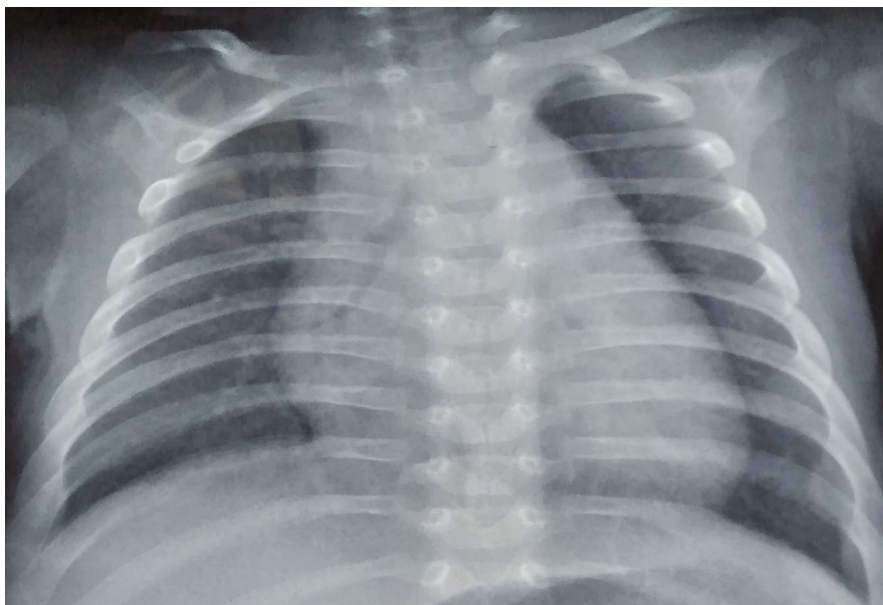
Chest radiograph showing moderate cardiomegaly associated with pulmonary overcirculation in an infant with supracardiac total anomalous pulmonary venous return.
